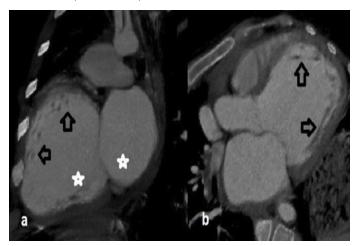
Two-chamber (a) and three-chamber (b) views of the cardiac computed tomography reveal the predominantly left atrial and left ventricular dilatation (asterix) along with apical and midventricular increased trabeculation (arrows).
